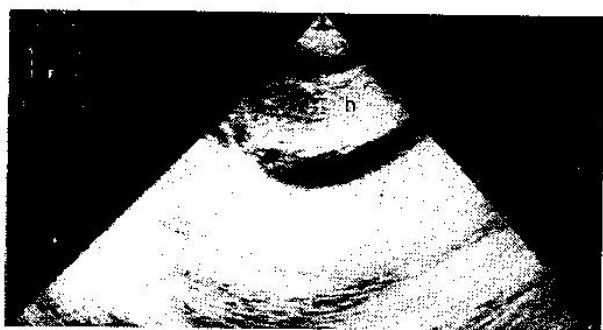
Real-time ultrasound image showing a portion of the large cystic loculated mass situated in the left upper abdomen with an echogenic structure within the lesion representing the intracystic haemorrhage (h)
